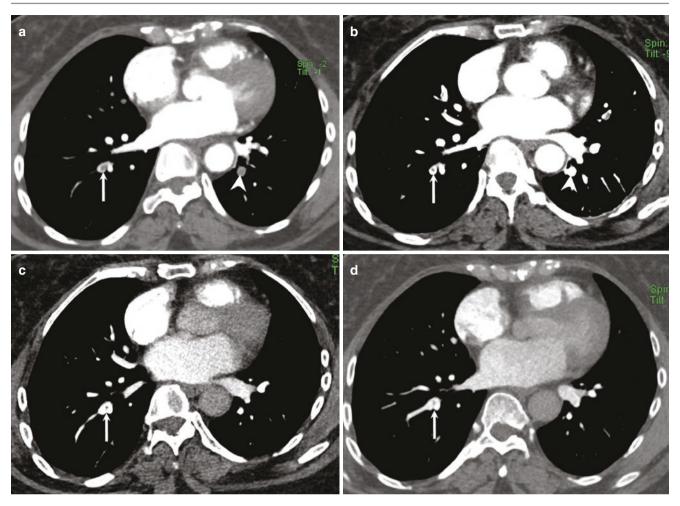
Serial follow-up of acute PE showing its evolution to chronic PE on warfarin. (a) CTPA on the day of the presentation. (b) CTPA on the third day. (c) CTPA after 1 year. (d) CTPA after 2 years. Initial CT shows a nonocclusive filling defect in a segmental branch of the right lower lobe
